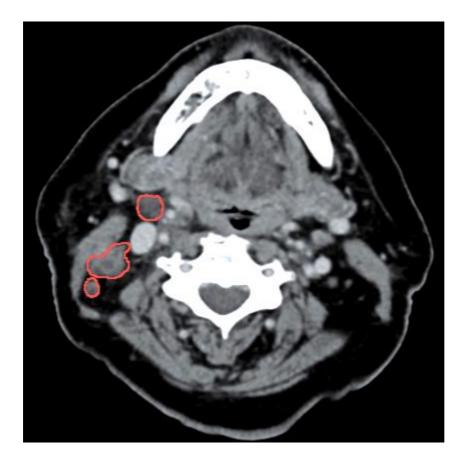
Pre-operative CT axial image at the level of the cervical level III and Va region
